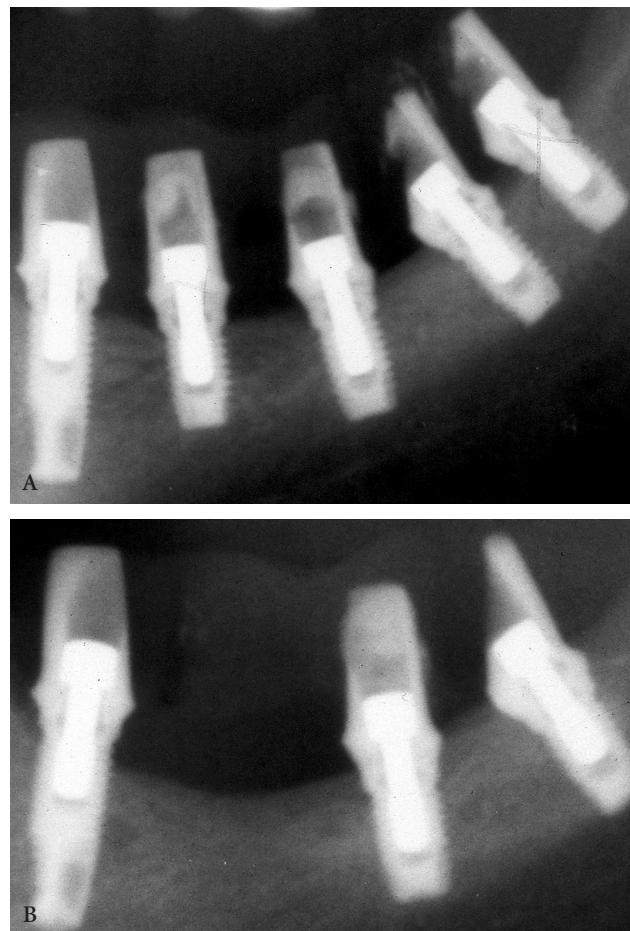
A*, Radiograph of patient 5 showing five implants loaded after 2 months of healing in the posterior mandible. Arrows point to implants to be removed. *B*, Radiograph after retrieval of two implants.
